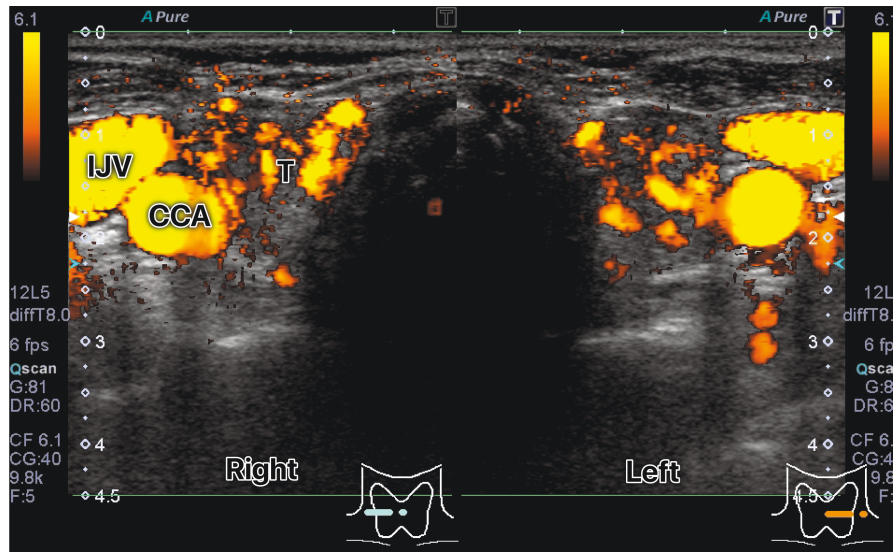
Color Doppler ultrasound findings of the patient on admission. A thyroid examination with color Doppler ultrasonography revealed a diffusely increased blood flow, which is typical of untreated Graves’ disease. Abbreviations: IJV, internal jugular vein; CCA, common carotid artery; T, thyroid gland.
